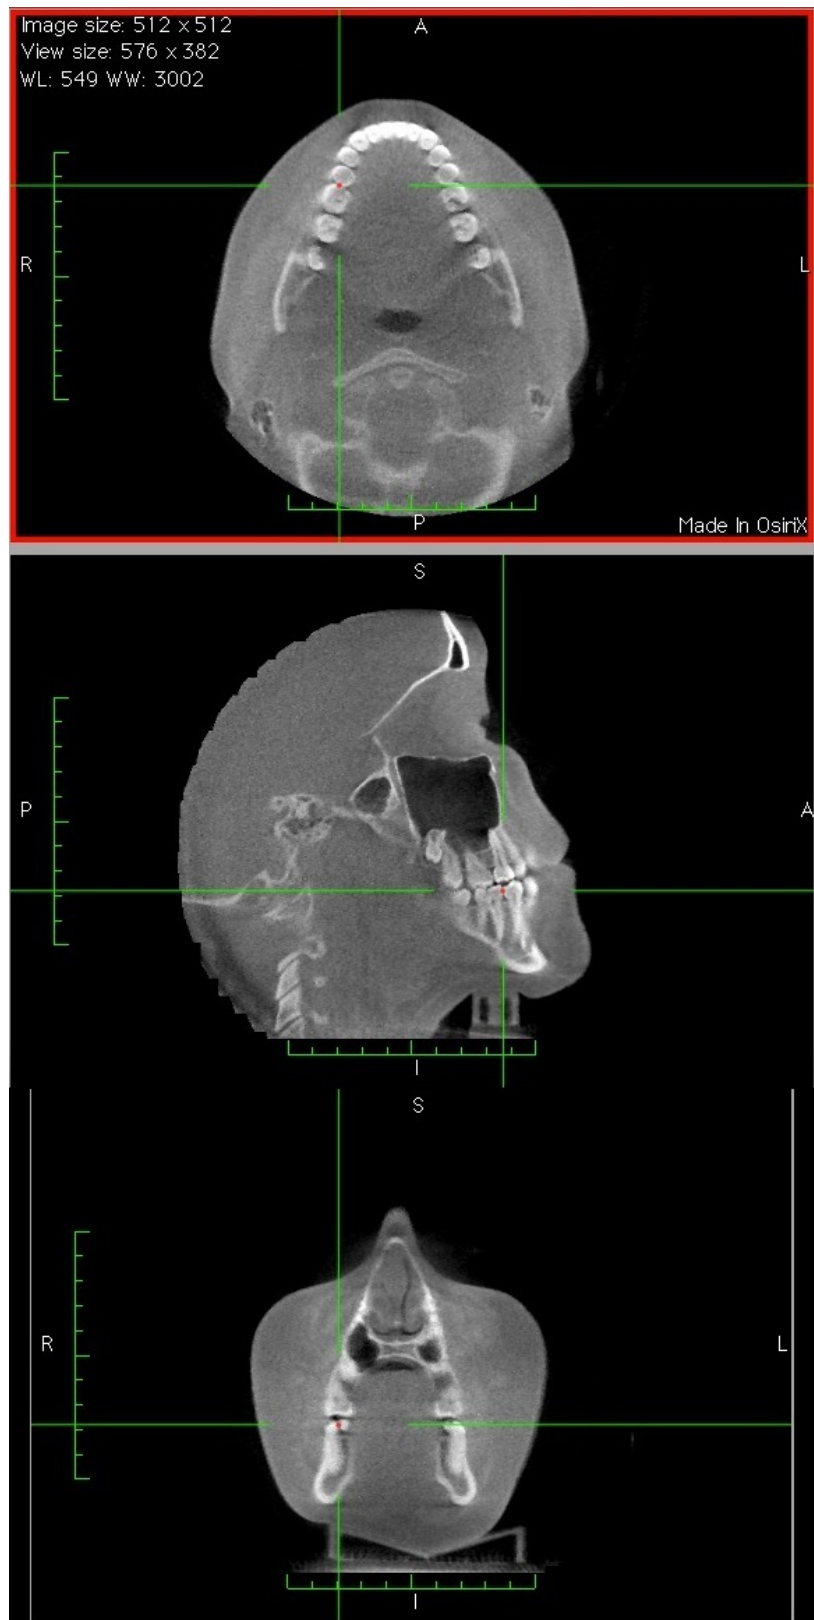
Method 1: CBCT MPR - CephalometriX™ Plugin using MPR View.
